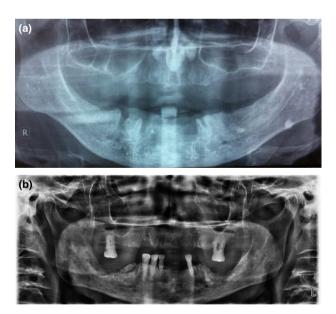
Orhtopantomograms of patients who have received radiotherapy (external beam radiotherapy with standard field sizes, conventional fractionation and mean dose 64 Gy) for oropharyngeal cancers. The patients underwent extractions of teeth of the lower jaw after completion of radiotherapy. The orthopantomogram revealed radiolucencies indicating post extraction sockets, which remained visible for longer than 12 months (a), as well as increased radiodensity with mixed radio-opaque/radiolucent lesions, where the radiolucent areas represent bone destruction (b).
